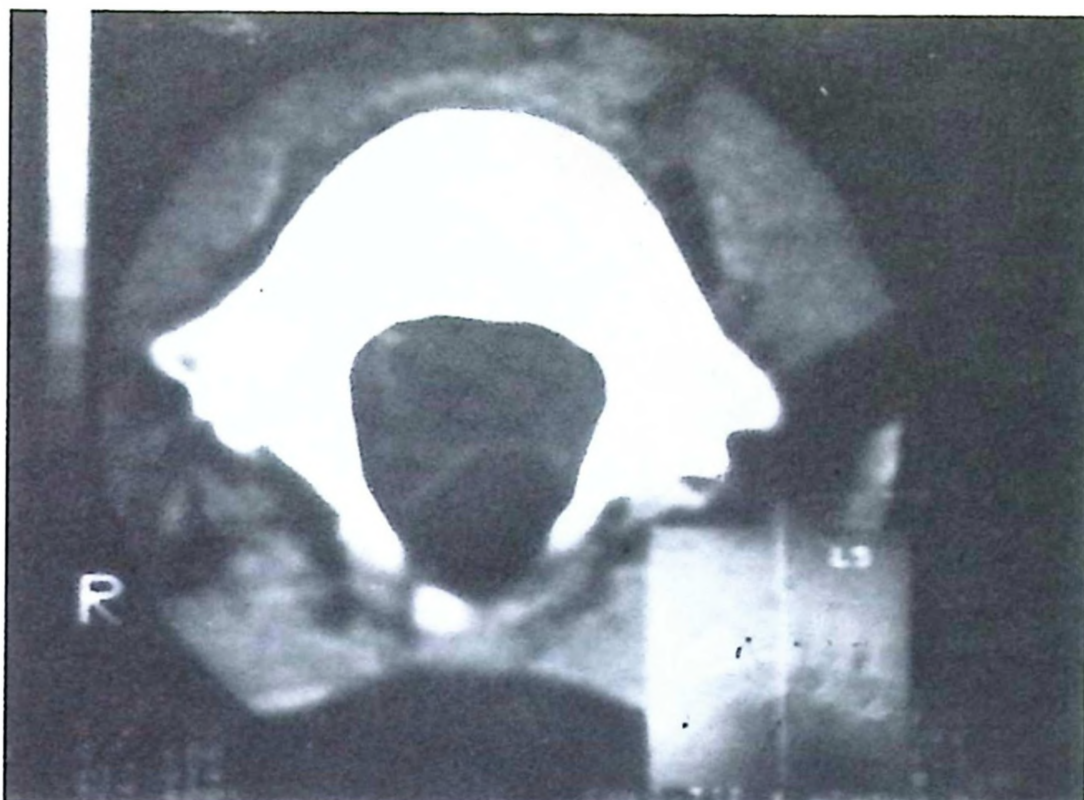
Spina bifida and intracanalicular lipoma (hypodense) on computed tomography.
